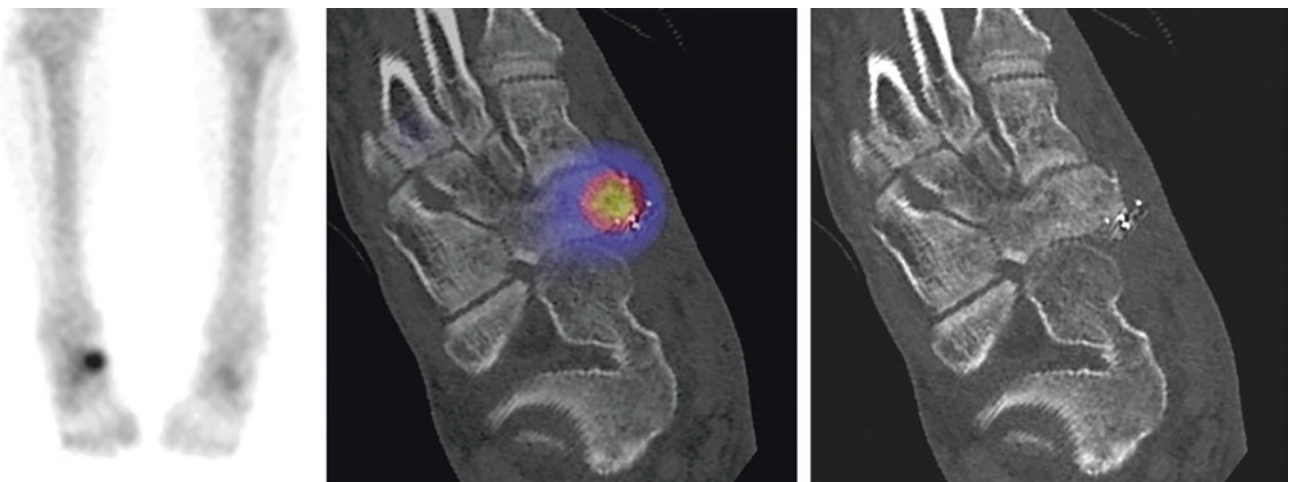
^{99m}Tc Bone scintigraphy performed in a patient who had suffered a bullet injury to the right foot about 1 year earlier. Planar scan (left panel) discloses a hot spot in the right midfoot. On the fusion SPECT/CT image (center panel), an area of the navicular bone exhibits
